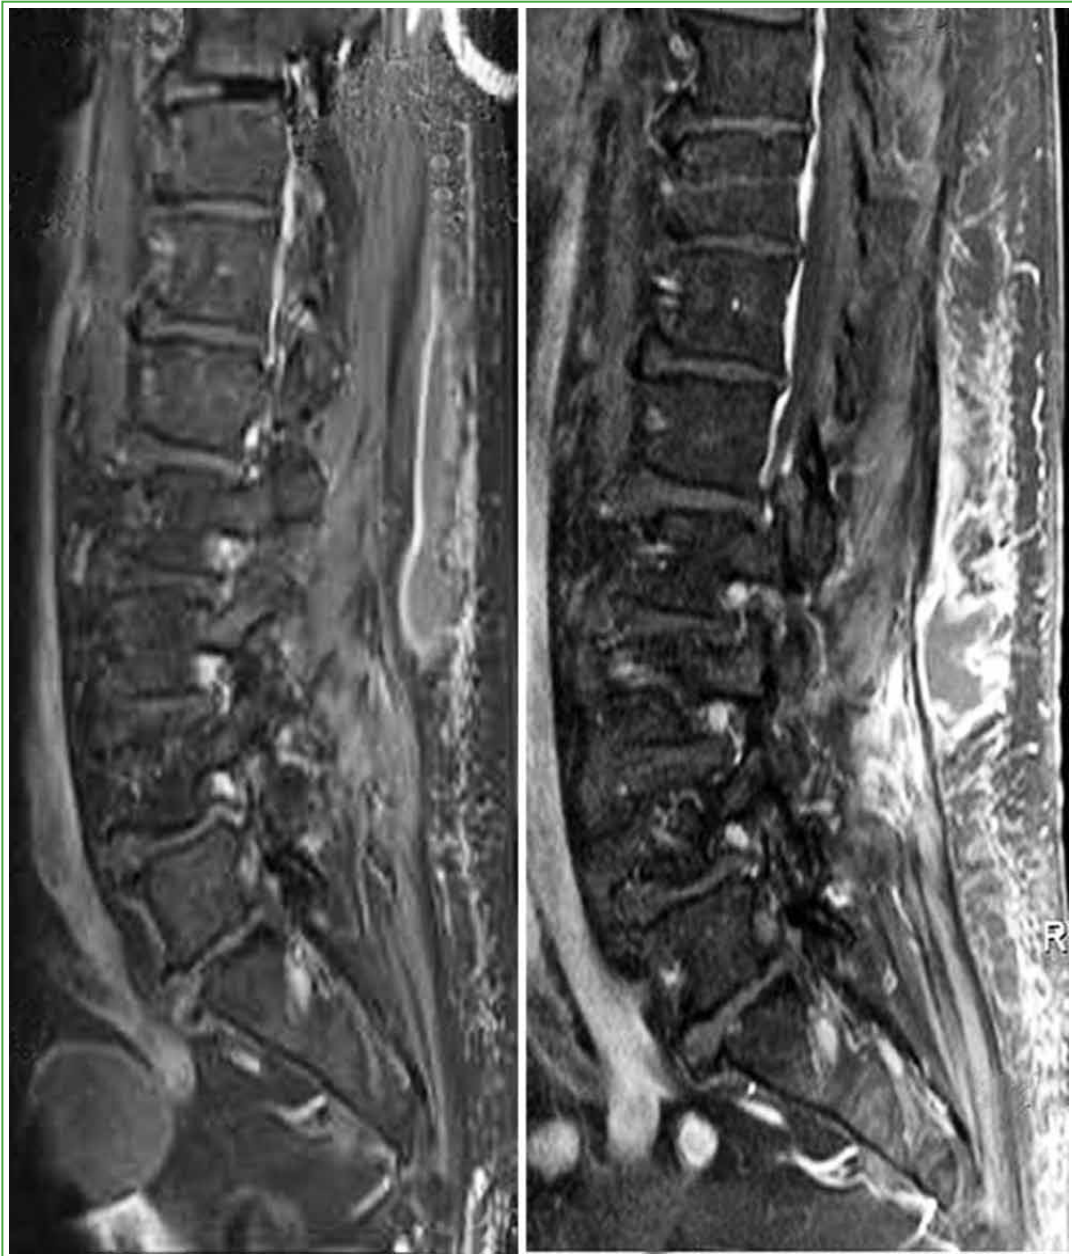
Sagittal view of a lumbar spine MRI showing a fluid collection at the level of the right paraspinal muscles, extending from T12 to L4.
